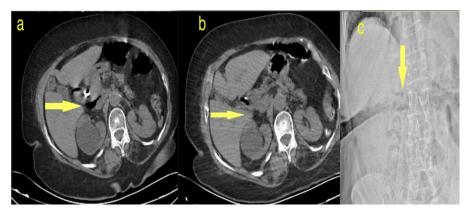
(a) Type 2 perforation with free air in the anterior side of the right kidney and the inferior vena cava. CT (b) and plain radiograph (c) of perforation resolution 72 hours after SEMS insertion.
